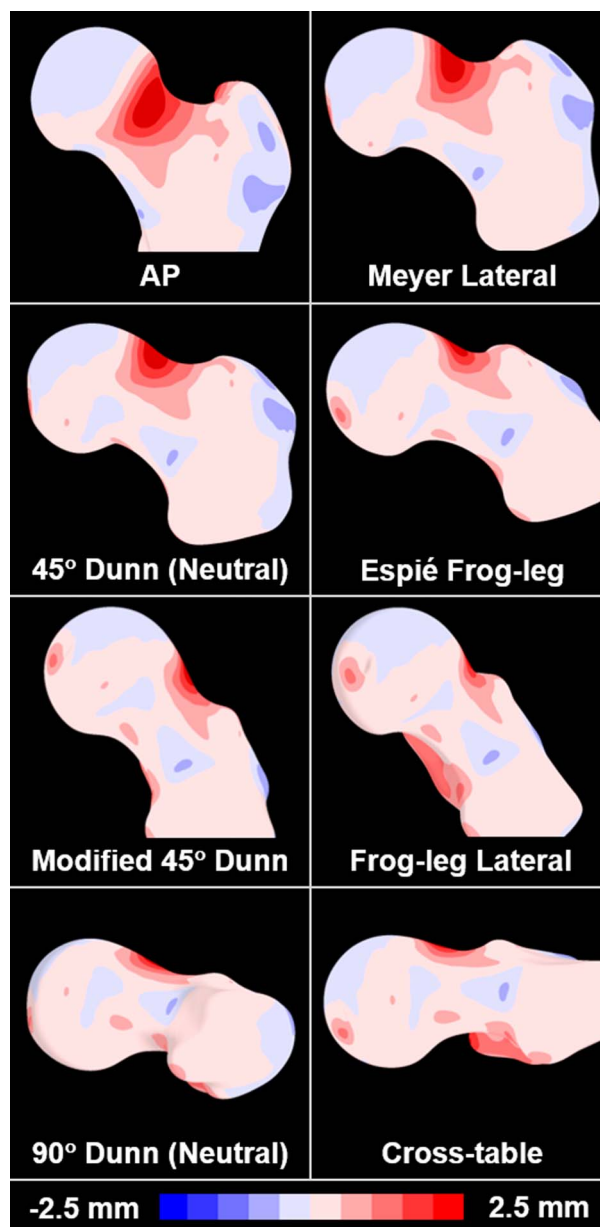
The mean cam femur from SSM was aligned to the orientation of the eight digitally reconstructed radiographs to visualize the location and magnitude of the cam lesion relative to the imaging plane. The color map represents the spatial distance between the mean cam and mean control surface reconstructions.
